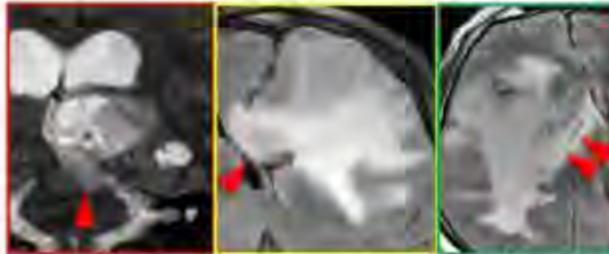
Deep white matter structures invasion. Images of different patients with glioblastoma IDH wildtype, without BRAF^{V600} mutation. On the left panel, the heterogeneous T2/FLAIR signal abnormality extends to the left cerebral peduncle. The middle image shows involvement of the genu of the corpus callosum by the mass-like T2/FLAIR hyperintensity. On the right frame, the extensive T2/FLAIR changes surround and splay the corticospinal tract fibers within the posterior limb of the internal capsule.
